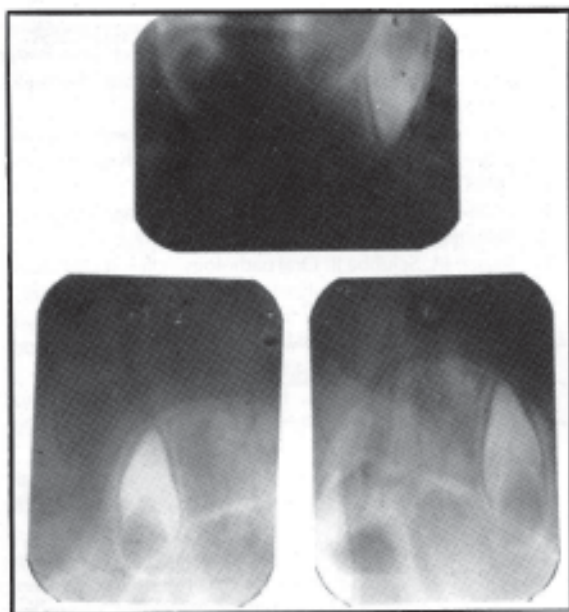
Periapical dental radiographs showing 4 cone-shaped crowns.
